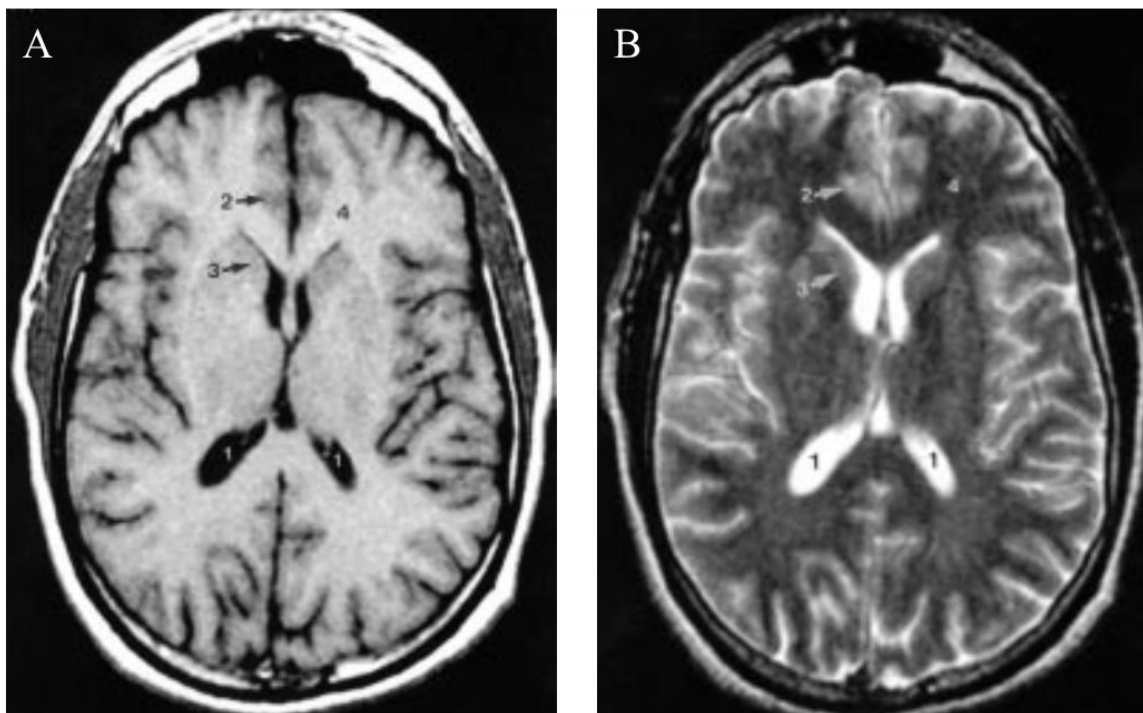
(A) T1-weighted axial MR image shows relative signal of cerebrospinal fluid (1) that is darkest, followed by gray matter (cortex, 2; basal ganglia, 3), and white matter (4). (B) On T2-weighted axial MR image, cerebrospinal fluid (CSF) (1) is brightest, followed by gray matter (2,3), then white matter (4) [7].
